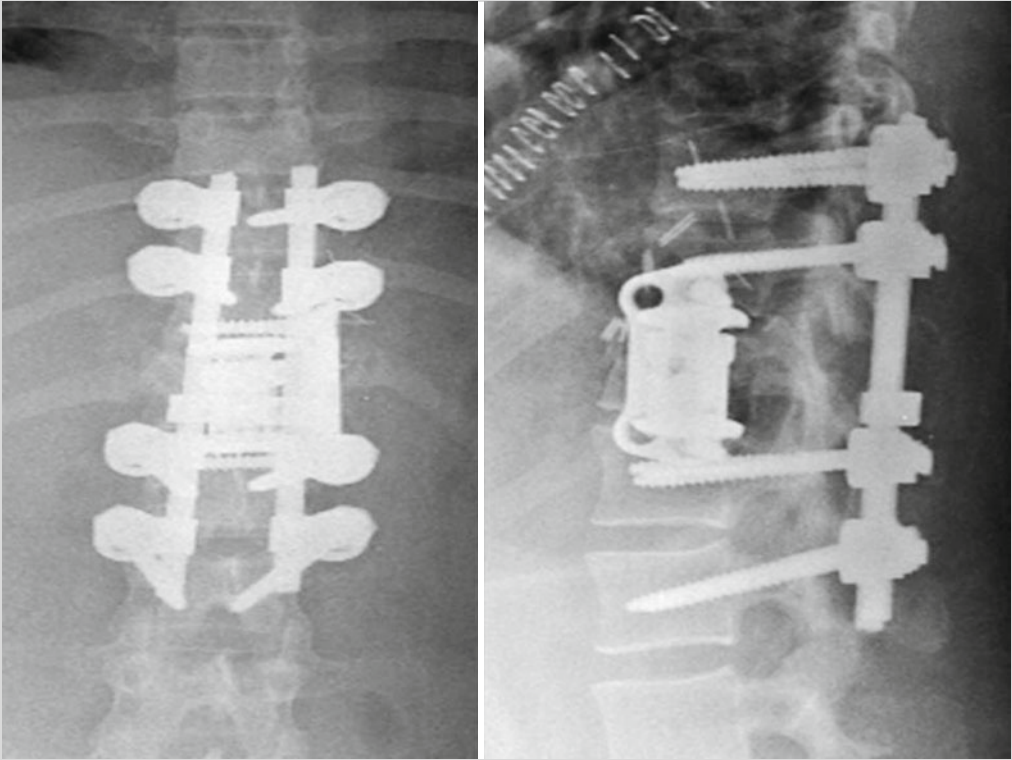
Anteroposterior and lateral radiographs after definitive treatment of the spinal injury to include corpectomy of T12, cage reconstruction, and anterior spinal fusion with instrumentation T11–L1. This
